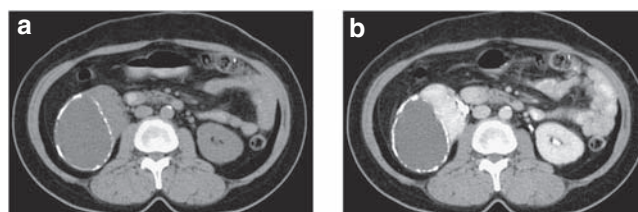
A Subcapsular renal hematoma is surrounded by a thickened and calcified wall with an apparently compressed right kidney. Computed tomography without (a) and with (b) contrast.
